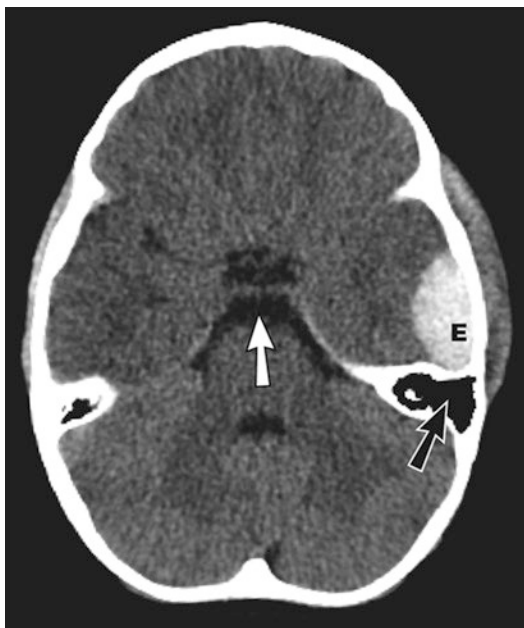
CT scan showing a left temporal acute epidural hematoma (E). Notice that the convex-lens shaped blood clot (E) has a density higher than brain but less than bone. Can you make out the boundary between the bone and the blood clot? You should linger here a little and ‘absorb’ the difference in density between the bone and the blood! Just behind the hematoma, the air in the mastoid (black arrow) is darker than the CSF in the center of the brain (white arrow). The CSF has a faint granular hue on close inspection which is absent in air
